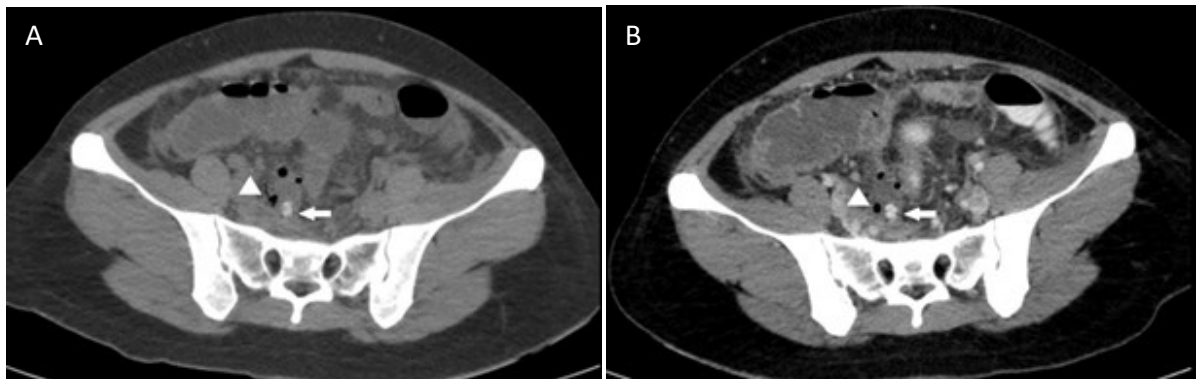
A case that diagnosed ruptured appendicitis in both unenhanced and IV-contrast enhanced scan in a 28-year-old woman with right lower quadrant pain. On axial CT images of unenhanced CT (A) and IV-contrast enhanced scans (B) show similar findings of enlarged fluid-filled appendix, measuring 1.2 cm in diameter with extraluminal air (arrowhead) and a 0.7-cm appendicolith (arrow).
